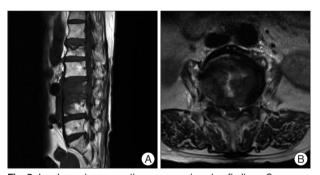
Lumbar spine magnetic resonance imaging findings. Space occupying lesions suggesting an epidural hematoma compressing thecal sac are seen (A). Epidural space occupying lesions extending from the L2 to L4 spines are evidnet (B). Compression fractures of the L1, L3 and L4 bodies rather than pyogenic infection or metastasis.
